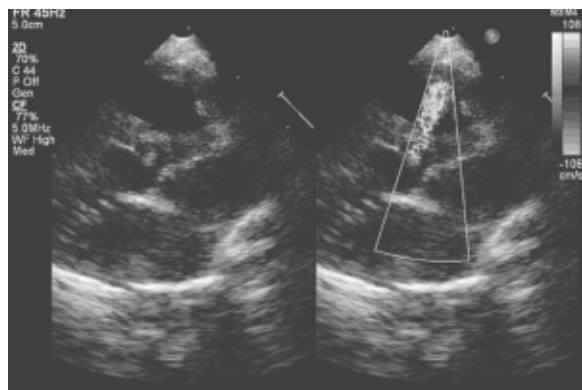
Echocardiography showing residual VSD
